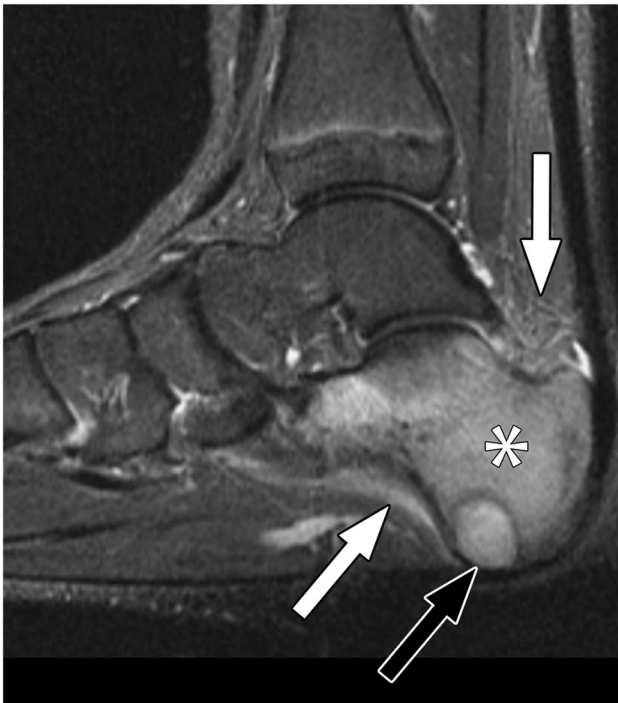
12-year-old girl with osteomyelitis due to disseminated blastomycosis. Sagittal T2-weighted fat-saturated MR image of the foot shows bone marrow edema throughout the calcaneus (asterisk), an intraosseous abscess (black arrow), and mild surrounding soft tissue edema (white arrows)
